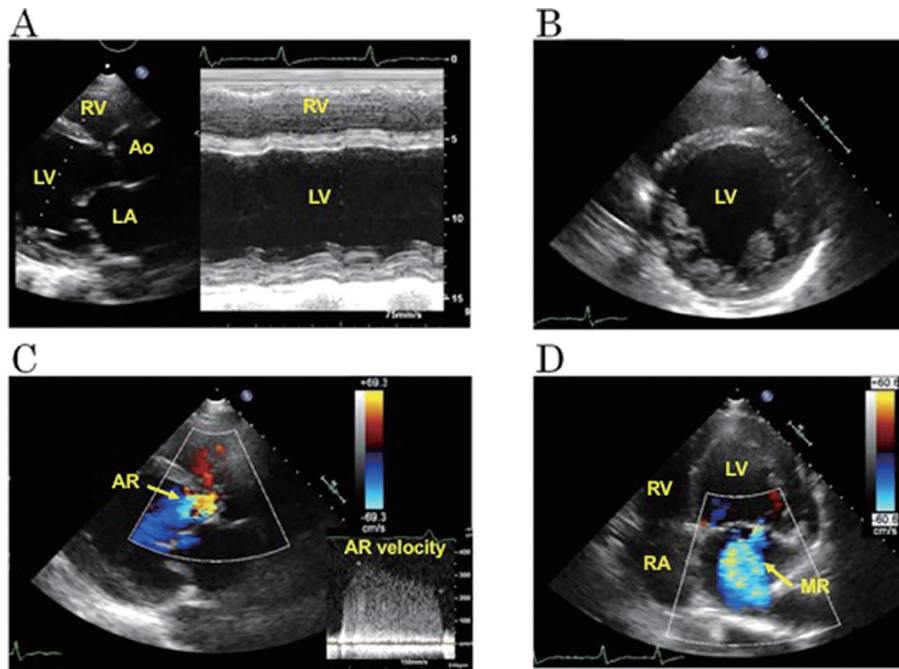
Echocardiography on admission showed a dilated LV cavity (LV end-diastolic dimension, 7.8 cm ; LV end-systolic dimension, 7.1 cm) and reduced LV wall motion in the parasternal long-axis view (A) and short-axis view (B). Doppler echocardiography revealed severe aortic regurgitation (AR) (C) and moderate functional mitral regurgitation (MR) (D).
